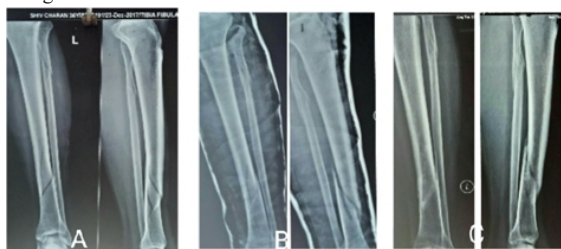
36 yrs old male patient (A) initial x-ray (B) at 4wks (C) at 14 wks
